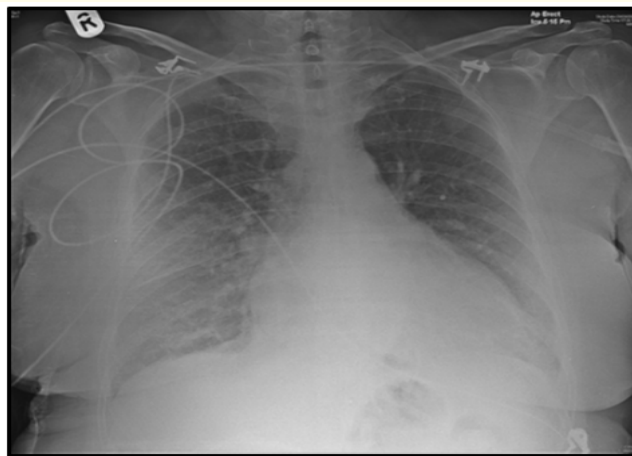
Portable anteroposterior chest radiograph showing cardiomegaly and overinflated lungs [13].
